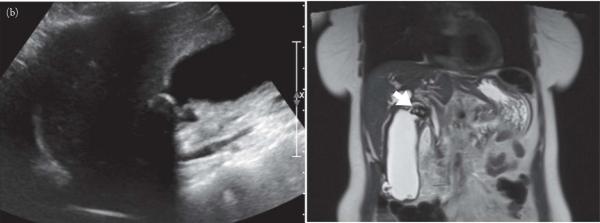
(a) Mirizzi syndrome types. The natural progression of Mirizzi syndrome begins with a gallstone in the neck or cystic duct. Recurrent episodes of outlet obstruction lead to chronic cholecystitis. This may lead to Mirizzi syndrome, which is external compression of the common hepatic or bile duct by a stone in the neck or cystic duct. As a result of recurrent inflammation and fibrosis, a cholecystobiliary fistula (CCBF) may form that forms a direct communication between the gallbladder and common bile duct (CBD). Grading of CCBFs are related to the severity of obstruction and destruction of the CBD, from 1/3 (Type II), 2/3 (Type III), and complete (Type IV) destruction and obstruction of the CBD. Adapted from Figure 1 of Csendes A, Díaz JC, Burdiles P, Maluenda F, Nava O. Mirizzi syndrome and cholecystobiliary fistula: a unifying classification. Br J Surg. 1989;76(11):1139–1143. (b) Mirizzi syndrome on ultrasound and magnetic resonance cholangiopancreatography (MRCP). In Panel (a), there is a large gallstone in the neck that, in the right clinical scenario (e.g., jaundice) would suggest Mirizzi syndrome. Note that ultrasound alone usually does not confirm the diagnosis. In Panel (b), MRCP shows a large gallstone in the neck that extrinsically compresses the common bile duct. Images courtesy of Monica Deshmukh, MD, and Shaden Mohammad, MD, Olive View–UCLA Department of Radiology.
